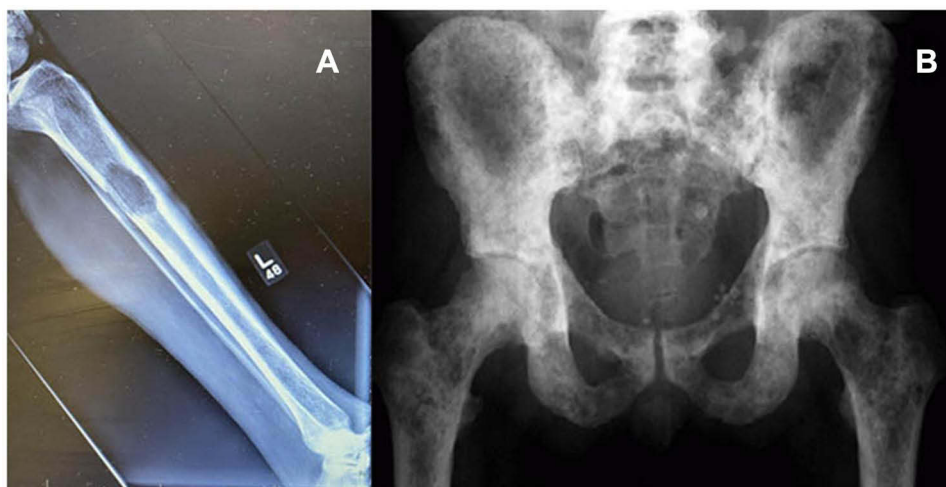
Anteroposterior radiographs showing: (A) Lytic bone lesion in tibial diaphysis. (B) Multiple mixed lytic and blastic/sclerotic bone lesions in pelvis.
